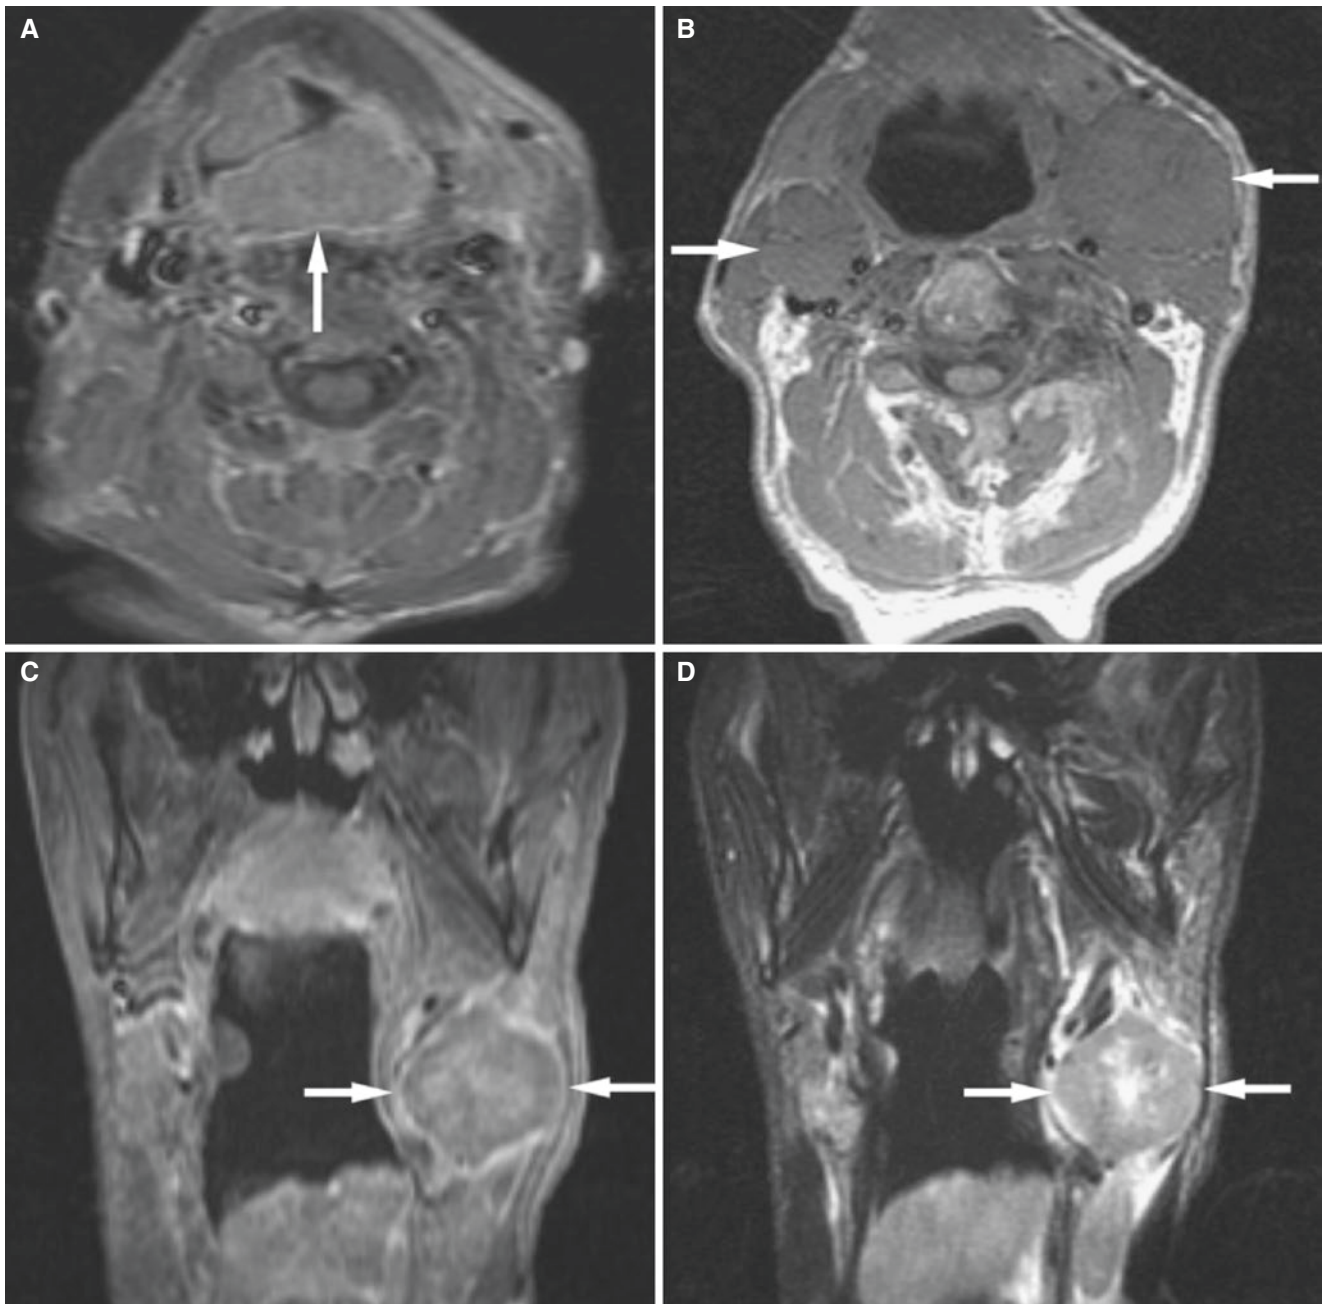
Hypopharynx carcinoma; 60-year-old female with a feeling of a lump in the throat. (A) Axial T1-weighted post-Gd fat-suppressed MRI shows a large almost circumferential hypopharyngeal mass (*arrow*). (B) Axial T1-weighted MRI shows bilateral enlarged
